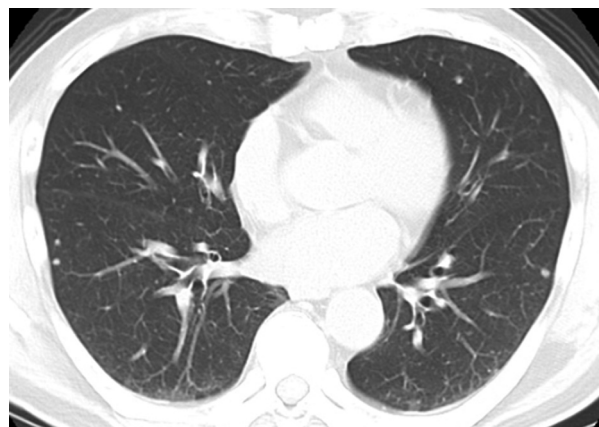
Chest computed tomography showed multiple nodular shadows in bilateral lung fields.
